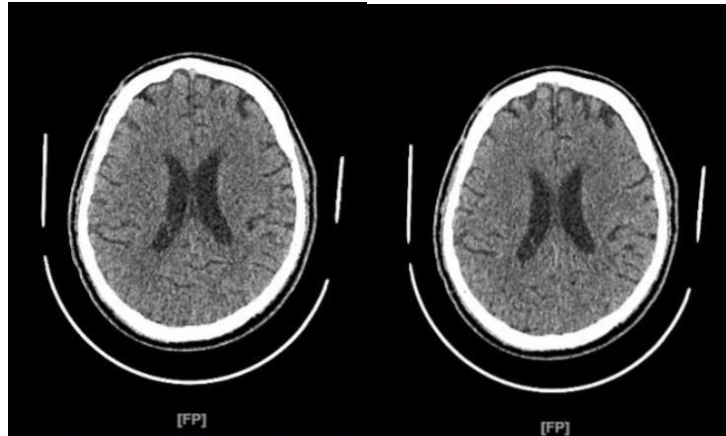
CT head of the patient that showed subacute lacunar infarct in the left posterior limb of the internal capsule
